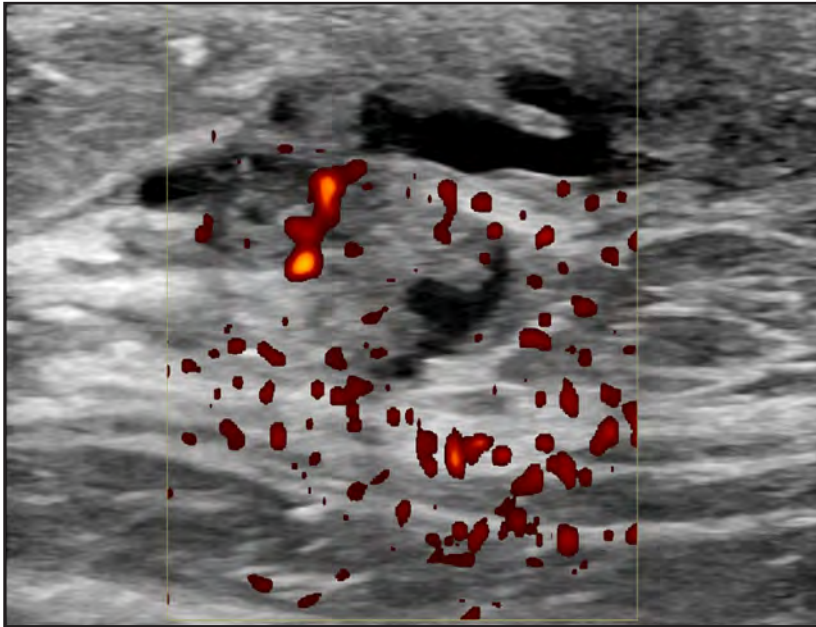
Power Doppler imaging in the sagittal plane demonstrates an intraductal mass in the right breast 1 o'clock subareolar location showing internal vascularity.
